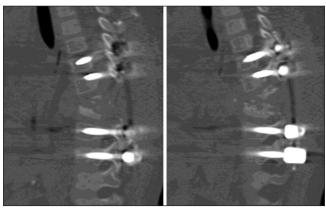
Postoperative CT showing kyphosis correction
